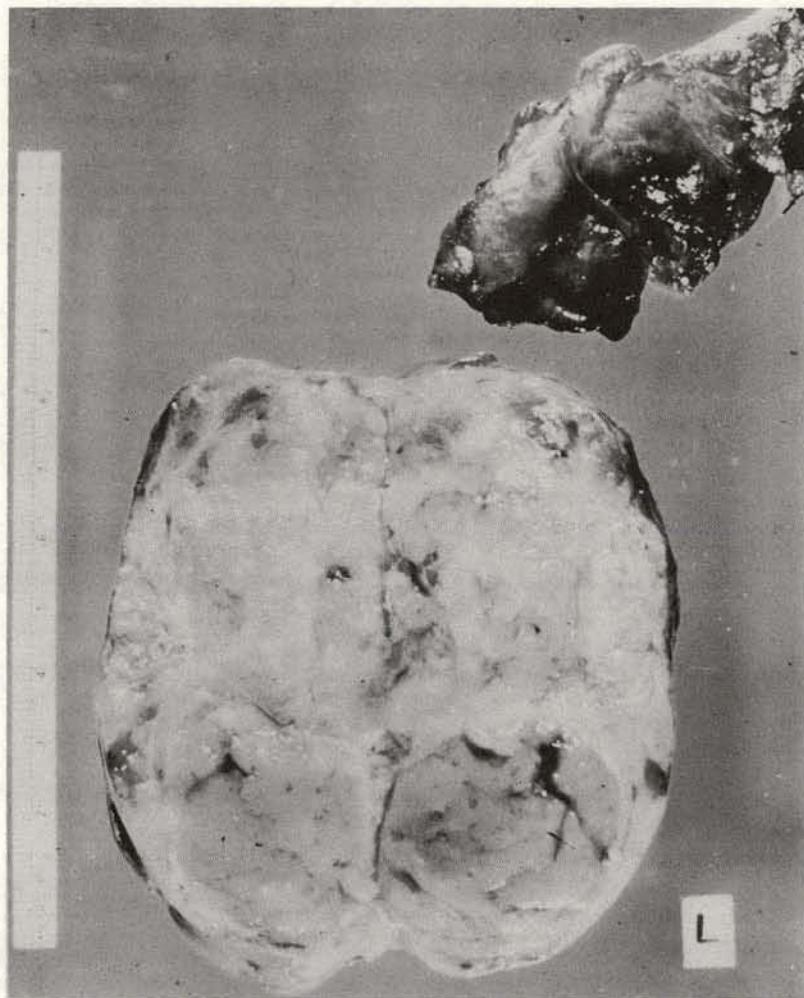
Benign mediastinal thyroid tumor removed from patient whose roentgenogram is shown in Figure 19.
